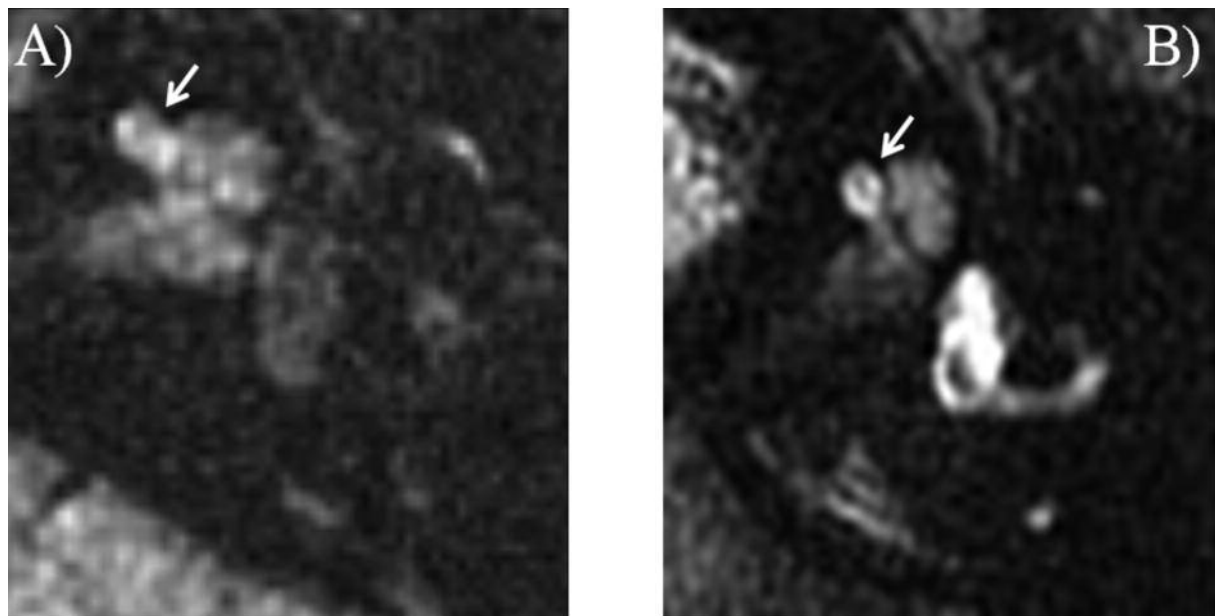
Fig. 2A shows a hydrops-negative cochlea from control patient, in which no enlargement of low signal intensity area was shown. 2D-FLAIR images of the inner ear (Fig. 2B), endolymphatic hydrops were seen at the cochlea as low signal intensity area surrounded by perilymphatic space with gadolinium enhancement.
